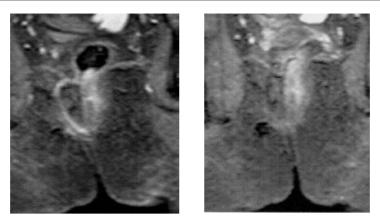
A case of transsphincteric perianal fistula. Coronal STIR sequence MR imaging showed high signal fistula tract which completely resolves after fibrin glue treatment.
